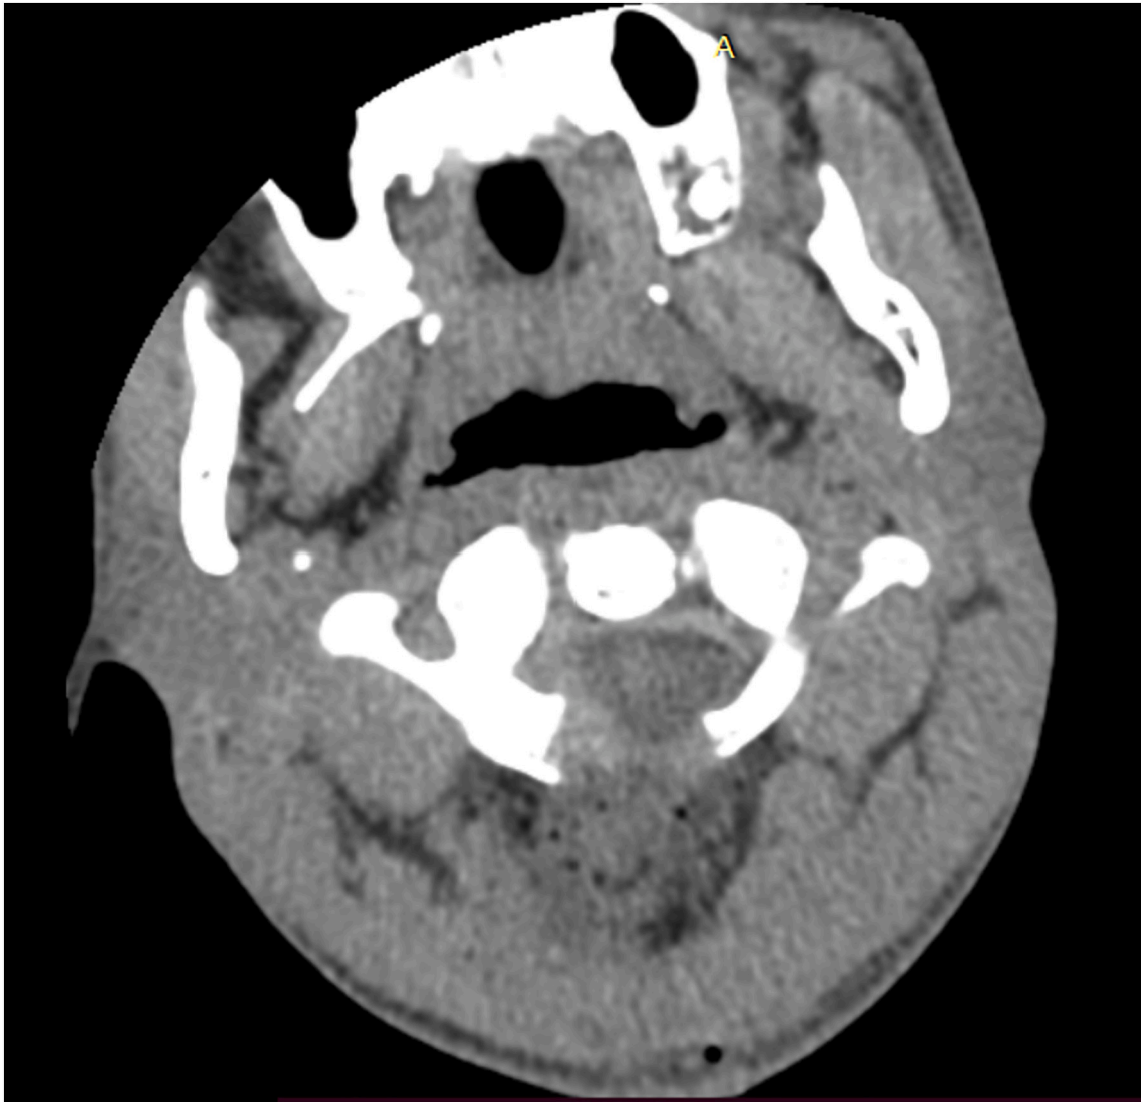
Post-operative cervical CT scan showing complete decompression of the cervical spine canal at C2 level.
